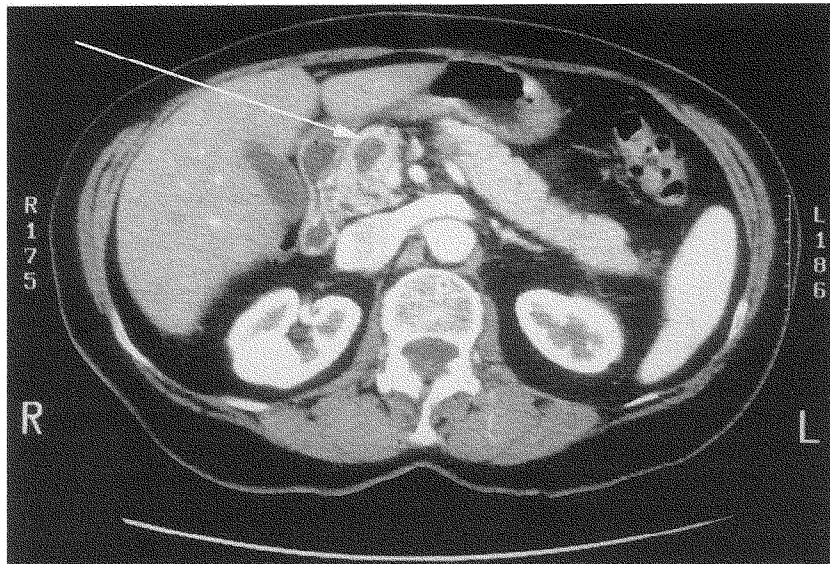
Helical CT scan with directed focus on the pancreas shows a 3 × 3 cm irregular, lobulated, cystic lesion (arrow) medial to the head of the pancreas. The mass does not appear to extend beyond the pancreatic margins or involve the pancreatic ducts.
